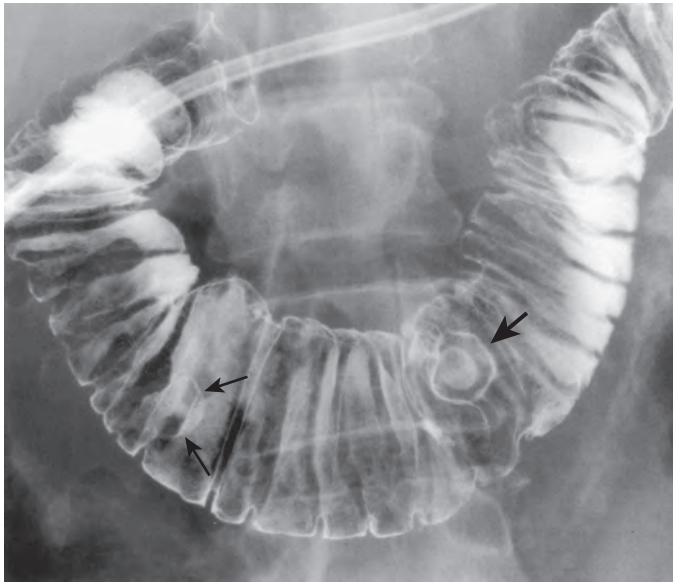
Hypotonic duodenogram. Upper endoscopy revealed a polypoid lesion in the duodenum. A radiographic study was requested for clarification. Spot image of the distal duodenum in air-contrast study shows a 1.8-cm polypoid lesion (*thin arrows*) etched in white in the second portion of the duodenum. A 2-cm polypoid lesion (*thick arrow*) is also seen at the junction of the third and fourth portions of the duodenum. Repeat endoscopy with biopsy and subsequent surgery revealed an adenocarcinoma of the second portion of the duodenum and a hemangioma of the fourth portion.
